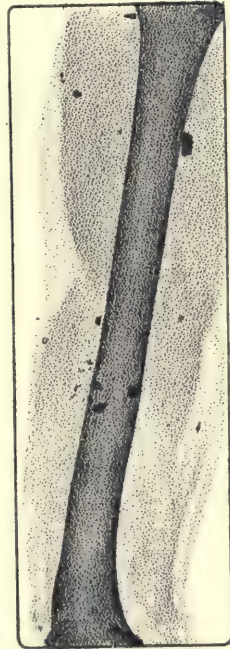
Radiograph of the left arm seen from its posterior aspect. Multiple metal fragments disseminated in the soft parts (grenade).
